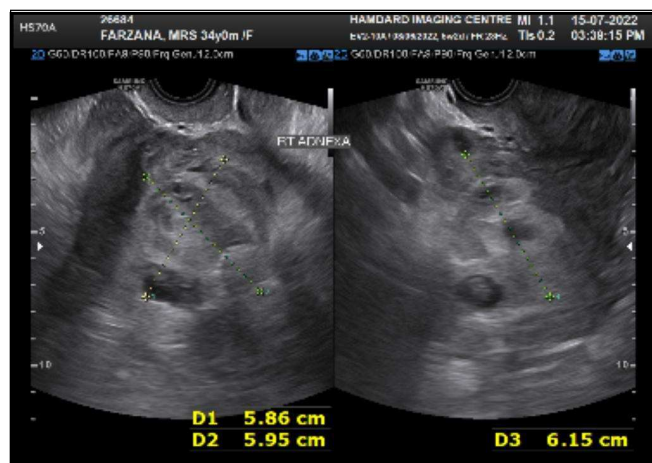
Ultrasonography showing right ruptured ectopic with hemoperitoneum
